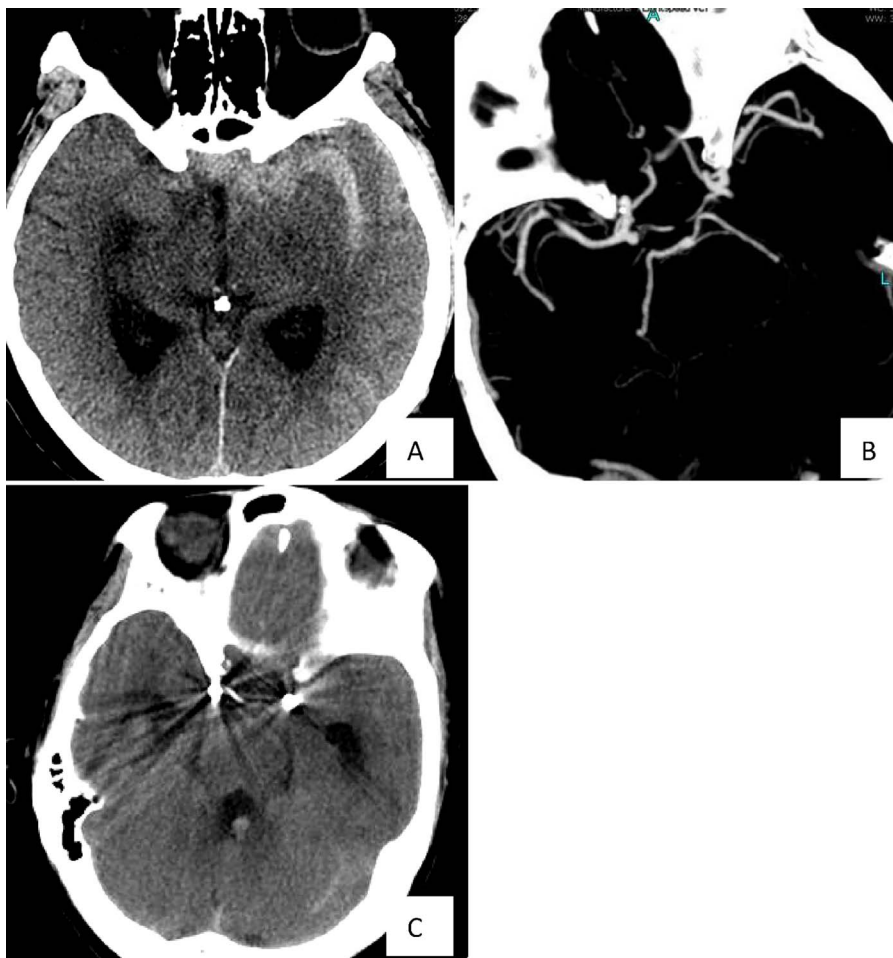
A. CT scan detected SAH with laterality (notably more blood agglomeration in the left bilateral than in the right bilateral). B. Maximum intensity projection image (with 10 mm slice thickness, window level and window width equal to the Hounsfield units within the aneurysm) detected that mirror aneurysms were located at ICA (symmetrically, same orientation). Mirror aneurysms in the left hemisphere was determined as the ruptured one based on SAH types. C. Examination of patients underwent vascular coiling after 7 days found that basically the SAH get absorbed and disappeared using plain CT scan, showing good prognosis (GOS, point 4) when discharge.
